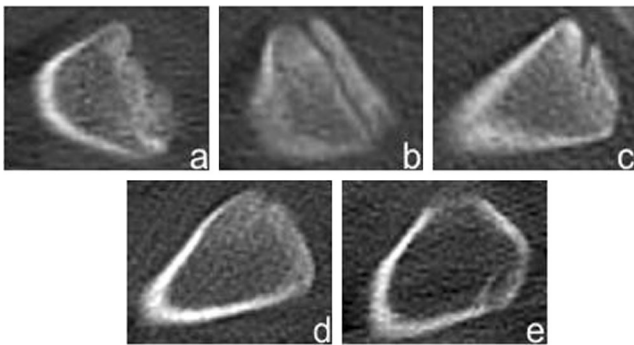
CT scan images of the ossification status of the medial clavicular epiphyseal cartilage (SIEMENS Syngo MultiModality Leonardo Workplace, bone window, original axial CT plane): a the first stage, b the second stage, c the third stage, d the fourth stage, e the fifth stage
